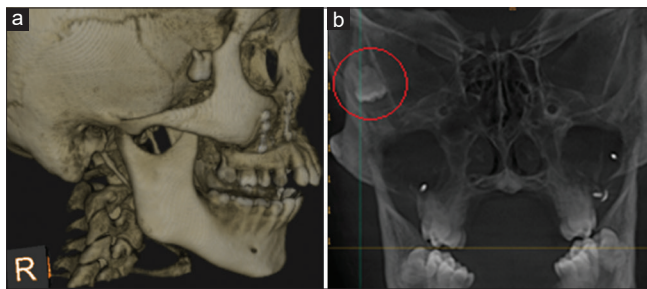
(a and b) Preoperative – cone beam computed tomography images showing location of the displaced right maxillary third molar
